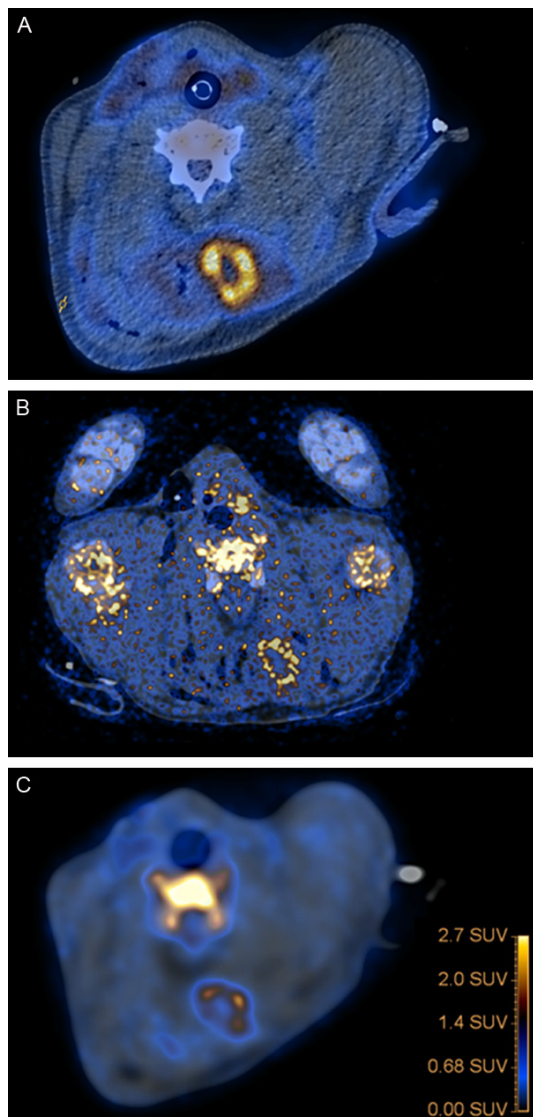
Fused PET/CT images of lungs with abscesses and axial views, with A:  $^{18}\text{F}$ -FDG, B:  $^{11}\text{C}$ -Methionine, C:  $^{11}\text{C}$ -PK11195, and D:  $^{68}\text{Ga}$ -citrate.
